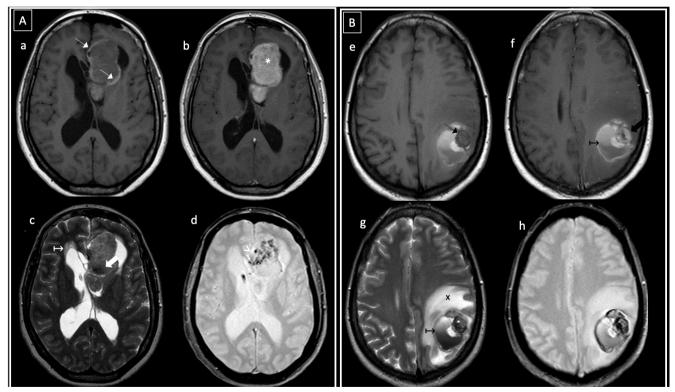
Intraventricular primary melanoma (A) and amelanocytic metastatic melanoma (B). In (A), a 46-year-old woman presented with headache. Axial T1WI pre and post-Gd (a, b) showed a heterogeneous left frontal intraventricular mass, with peripheral high signal areas (thin white arrows) and marked contrast enhancement (* in b). T2WI and GRE (c, d) showed hypointense foci (thick white arrows) and intratumoral magnetic susceptibility artifacts (white arrowhead). No restricted diffusion was observed (not shown). Hydrocephalus was present (white ⇔ in c). In (B), a 48-year-old woman with a history of cutaneous melanoma presented with seizures. Axial MRI images (e-h) showed a hypointense-T1WI left parietal intra-axial peripheral nodule (thin black arrow in e) with heterogeneous contrast enhancement (thick black arrow in f). The lesion was surrounded by hemorrhagic products and hematocrit level (black ↔). Extensive vasogenic edema was observed (black x in g).
